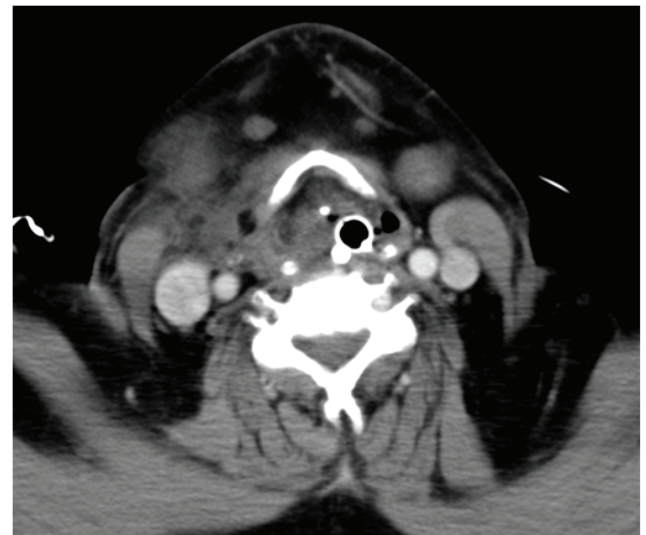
Interval axial CT scan image of the neck one week after initial presentation with an overall significantly improved appearance. Endotracheal and nasogastric tubes are seen *in situ*.
